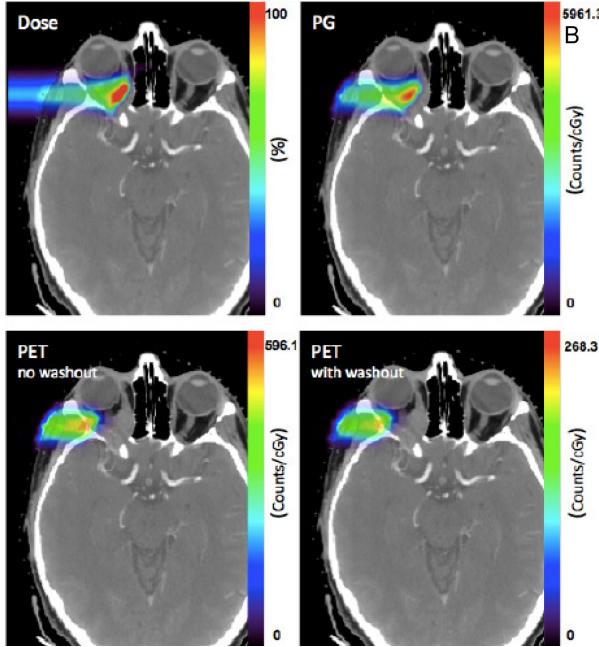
Dose verification on the CT image of a proton head-and-neck treatment. Top left, dose distribution; top right, prompt- γ counts; bottom left, PET counts without washout; bottom right, PET counts with washout. *Reprinted from [14].*
